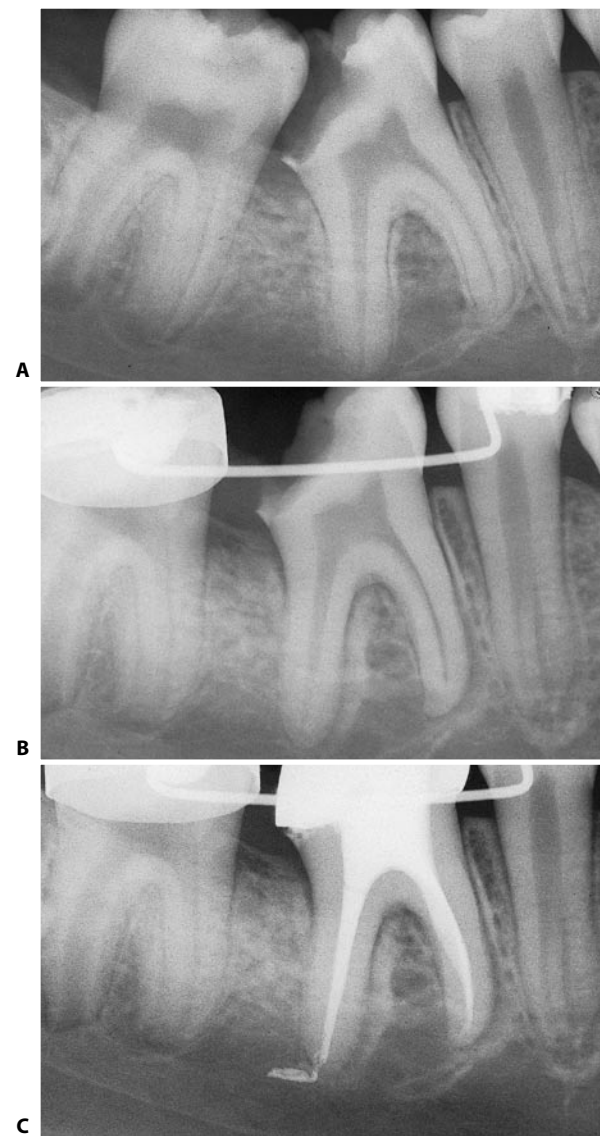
Radiographs obtained before (A) and after (B) orthodontic pretreatment. C. Postoperative radiograph.
